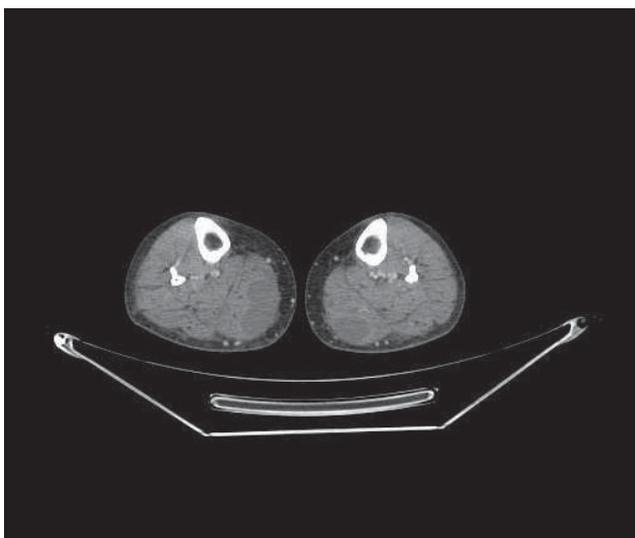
CT of the legs (axial vue): fluid encapsulated collections, well organized, with thin walls, heterogeneous serum and hemorrhagic densities, suggesting possible hematoma in bilateral gastrocnemius muscles.
